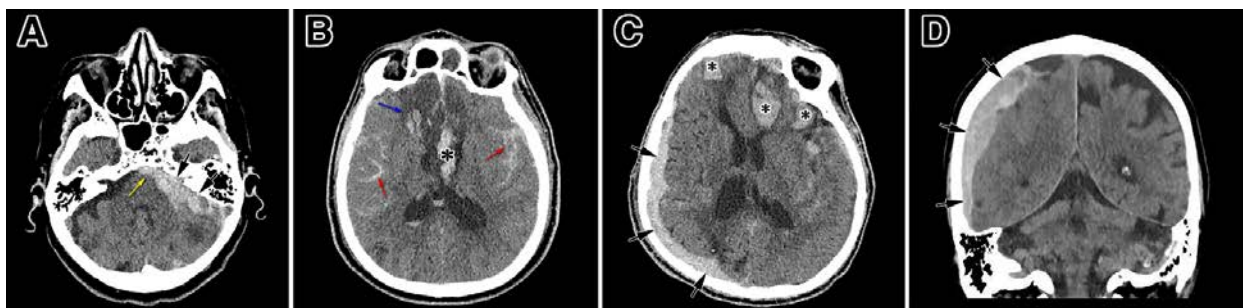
Infratentorial subarachnoid hemorrhage (SAH) in the basal cisterns (yellow arrow) and subdural hemorrhage on the left (black arrows) (A) in an axial computed tomography scan. Note a supratentorial SAH (red arrows) associated with a frontal parenchymal hemorrhage (PH) (blue arrow) and the intraventricular hemorrhage (IVH) (asterisk) (B), as well as a subdural hematoma (SDH) (black arrows) in the axial plane (C), and a right SDH (arrows) in the coronal plane (D), along with multifocal PH (D).
